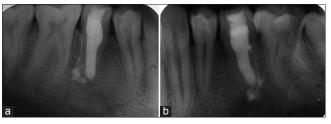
Postoperative intra-oral periapical radiographs showing healing of the periapical lesion. (a) Right mandibular premolars, (b) left mandibular premolars
